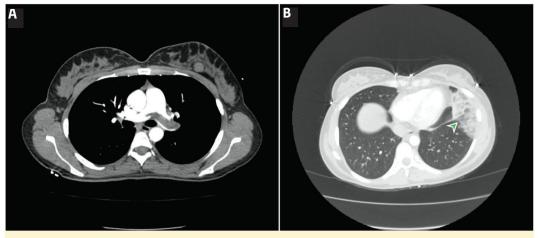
Contrast-enhanced multislice computed tomographic pulmonary angiography demonstrated a large thrombus in the left main pulmonary artery (A); and pulmonary infarction (arrow) in the lower lobe of left lung (B).
